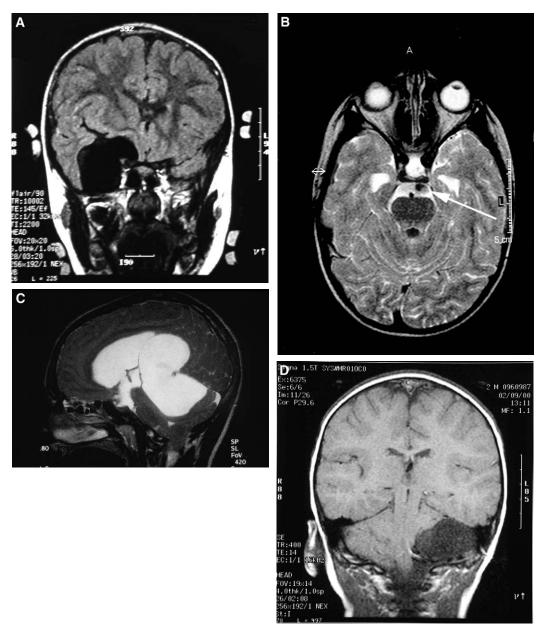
(A) Coronal T1-weighted MRI scan of middle fossa arachnoid cyst. (B) Axial T2-weighted scan of suprasellar arachnoid cyst's base with flow void seen at point of fenestration (arrow). (C) T2-weighted sagittal MRI scan of quadrigeminal arachnoidal cyst. (D) T1-weighted coronal MRI scan of cerebellopontine angle arachnoidal cyst.
